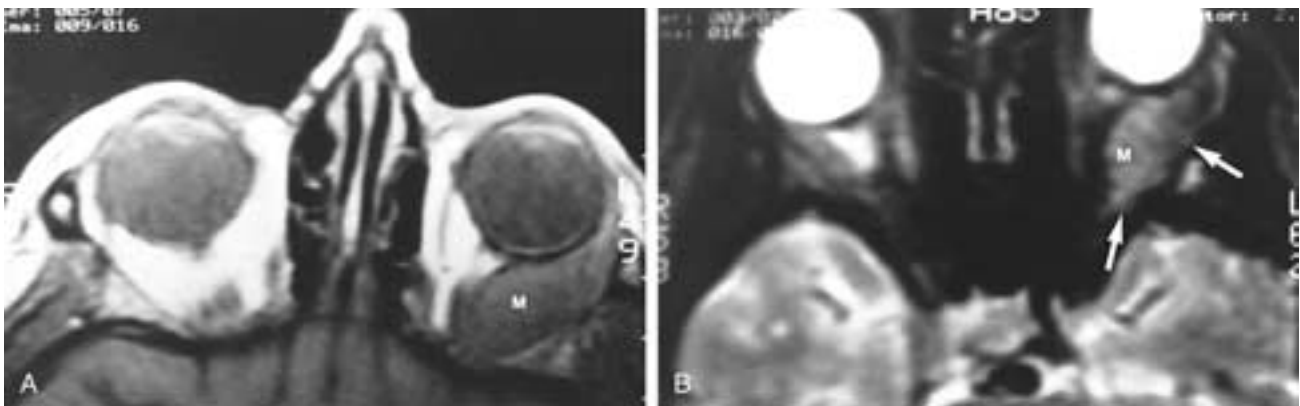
Adenocarcinoma of the lacrimal gland. (A) Axial T1-weighted MR scan and (B) Axial T2-weighted MR scan show a large mass (*M*). The lateral orbital wall is irregular (*arrows*). CT scans showed erosion of bone.
